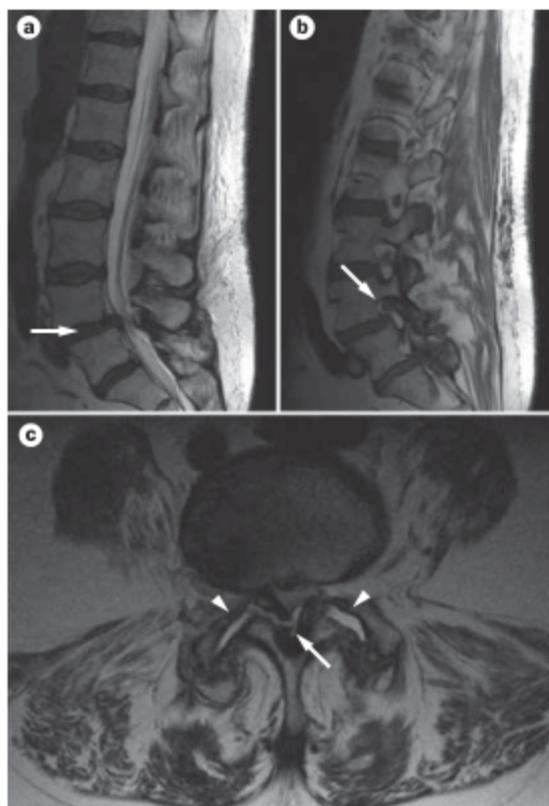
Spinal alterations in a patient with monosegmental LSS at L4–5. Sagittal and axial images were obtained using T2-weighted turbo spin-echo MRI. a | A sagittal image reveals reductions in the disc signal and the disc space height, which are attributable to dehydration. Disc bulging and slight ventral listhesis of L4 (arrow) can also be observed. b | Narrowing of the neuroforamen (arrow), which affects the right L4 radix, is caused by c | consecutive hypertrophic facet joint degeneration with intra-articular effusions (arrowheads) and hypertrophy of the ligamentum flavum (arrow), as observed on an axial image.
